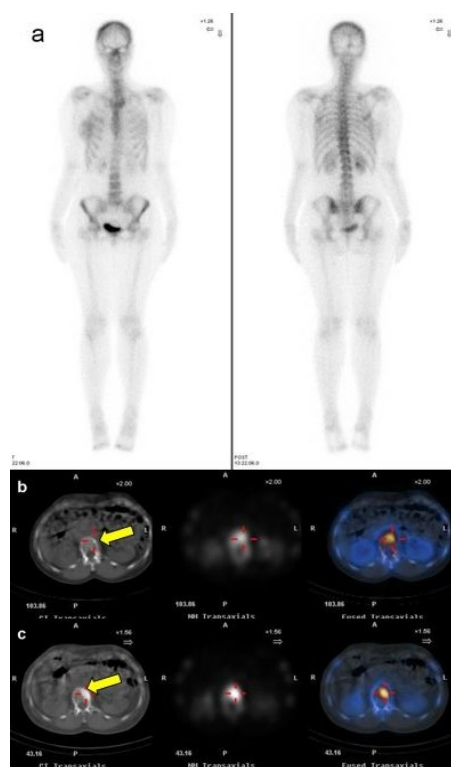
Images from a 37 years old female with lobular carcinoma of the left breast with liver and brain metastases at presentation (stage IV). Planar WBS (a) undertaken as part of the staging procedure was unremarkable. Low-resolution CT revealed a small osteoblastic lesion at the body of L1 vertebra which exhibited mild to moderate increase of metabolic activity (b). Single photon emission tomography/CT was interpreted as suspicious for metastasis. The evolution of the lesion is demonstrated on repeated SPET/CT study 10 months later (c), confirming the presence of a solitary bone metastasis (arrows).
